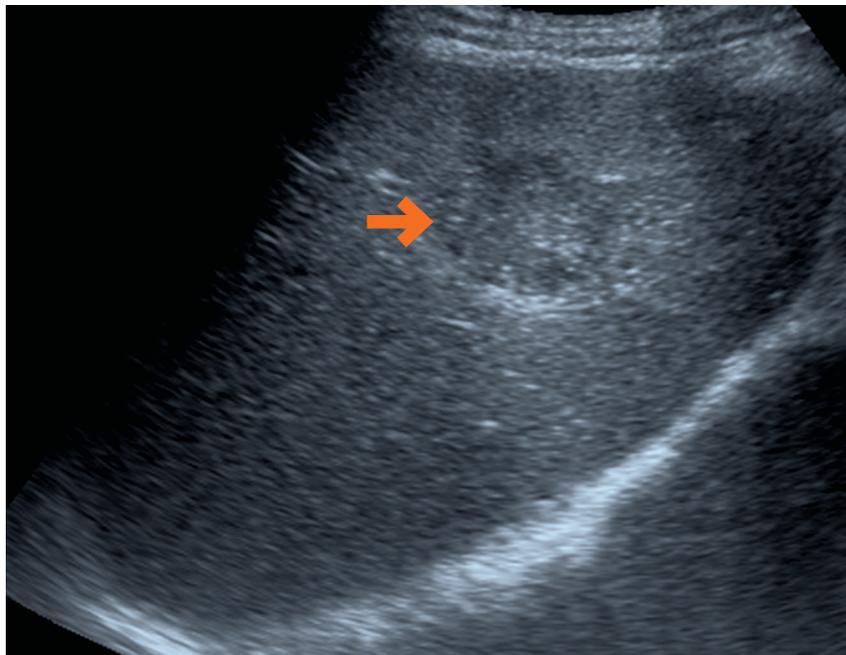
A focal liver lesion (arrow) on a background of mildly increased echogenicity. The patient had a previous sonographic examination suggesting the presence of a hemangioma in the liver; the appearances are not typical for a hemangioma, but in the presence of a fatty liver a hemangioma can be of low echogenicity.
